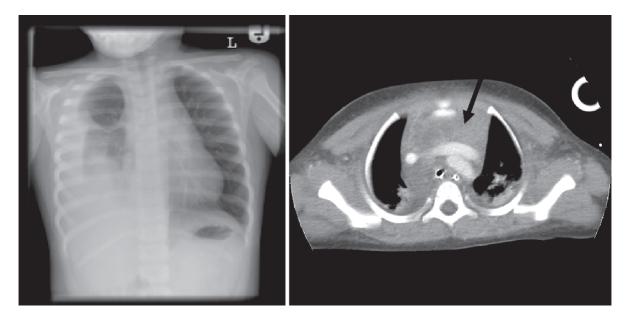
Chest X-ray and CT from a child with persistent chylothorax due to a mediastinal lymphatic malformation (arrow)
